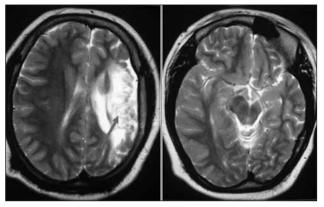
Axial T2 – weighted brain MR images showing left cerebral hemiatrophy (red arrow).
